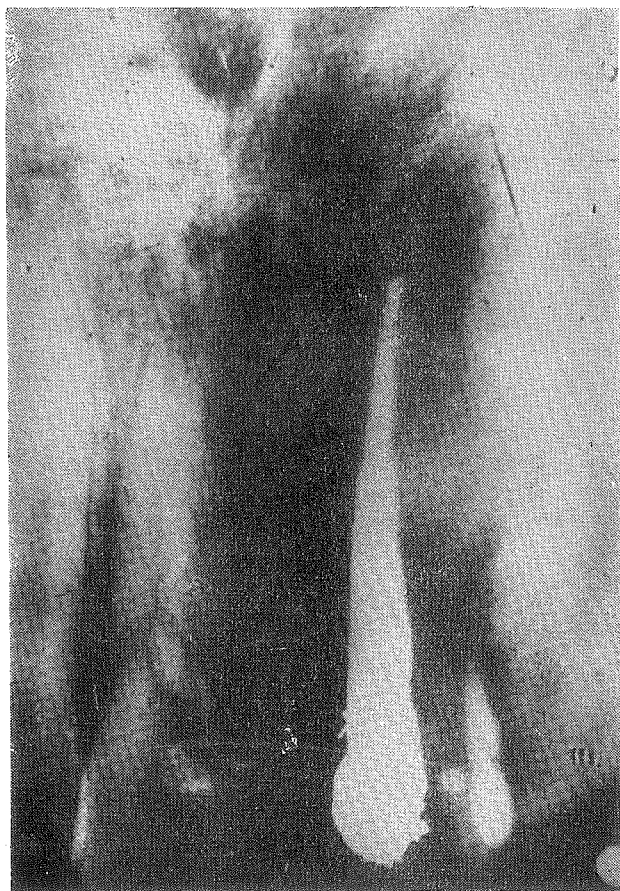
X-ray taken after one year shows the apical process has disappeared.
